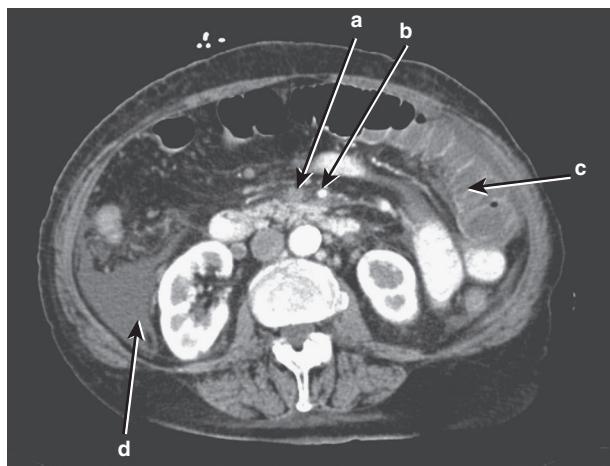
Multidetector computed tomography of the abdomen in the portal venous phase, in the axial projection, shows thrombosis of the superior mesenteric vein (*a*), an open superior mesenteric artery (*b*), dilated and edematous small bowel loops (*c*), and ascites (*d*).
